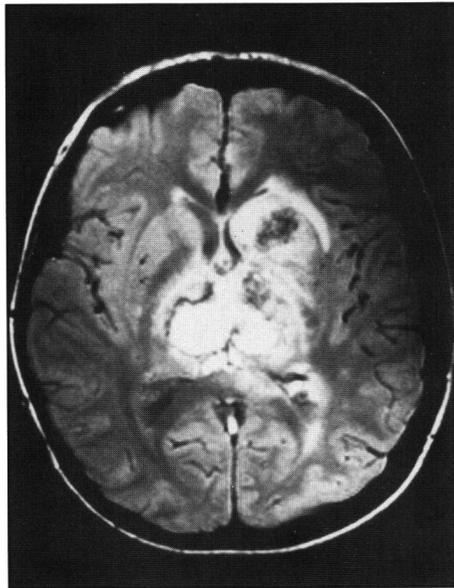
Patient 2 — Proton-density SE MR (TR = 2100ms, TE = 30ms) ten days after admission. Hyperintensity with rim hypointensity in the medial thalami and internal capsules indicating subacute hemorrhage. Hypointensity of left putamen, anterolateral left thalamus, left internal capsule and body of left caudate nucleus, which appeared hypo- to isointense on T1-weighted images (not shown), indicating more acute phase hemorrhage. Hyperintensity throughout remainder of deep cerebral structures. Mild bilateral lateral ventricular dilatation with hyperintensity adjacent to the anterior horns which, on the right, is not contiguous with white matter edema elsewhere, a pattern suggesting transependymal CSF resorption.
